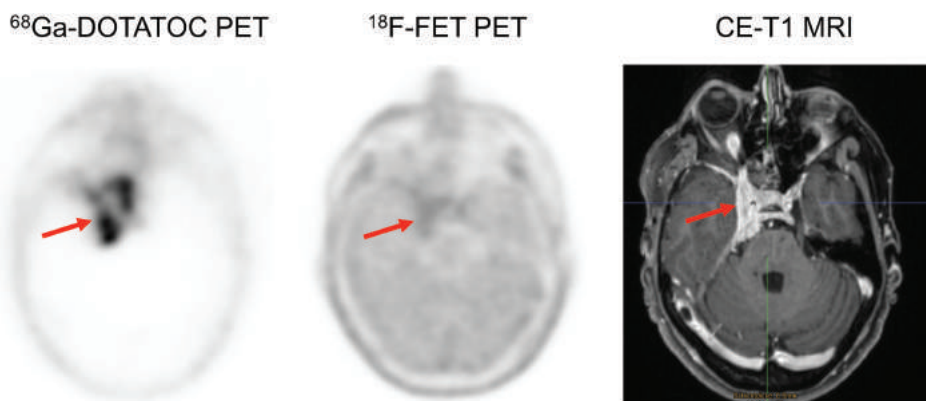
Patient with a WHO grade I meningioma (arrows). In contrast to structural MRI, particularly ^{68}Ga -DOTATOC PET delineates meningioma extent more precisely. For radiotherapy planning, the contralateral unaffected side can be spared.
